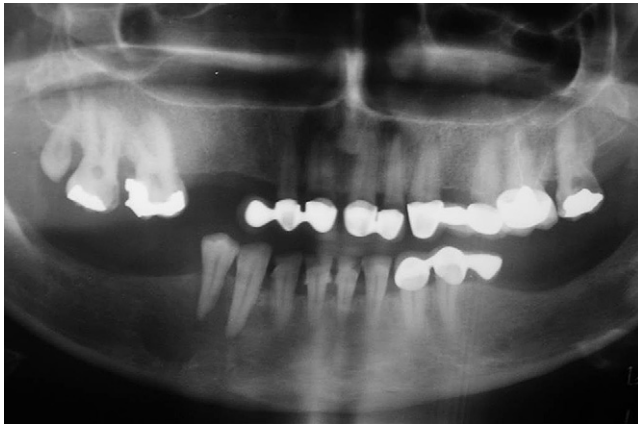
Unilocular well-circumscribed radiolucency with ill-defined border in periapical region of mandibular second premolar. Widening of the periodontal ligament is also noted.
